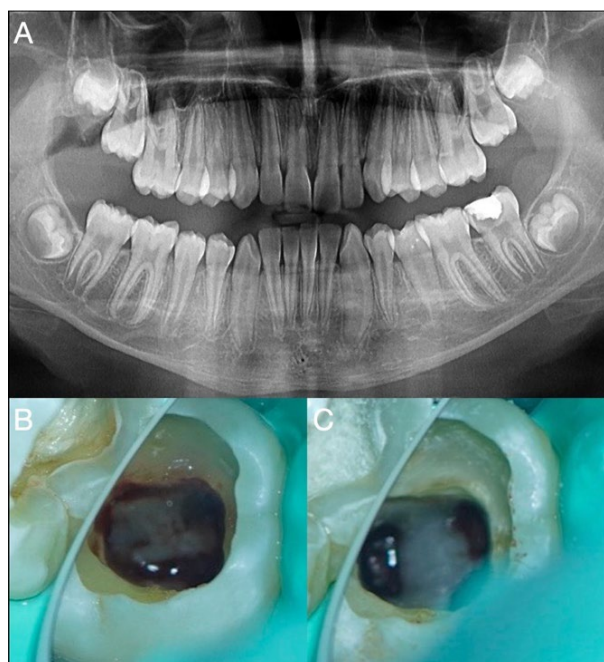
A) Panoramic radiograph showing deep caries; B) Endodontic access cavity; C) Control of hemostasis
